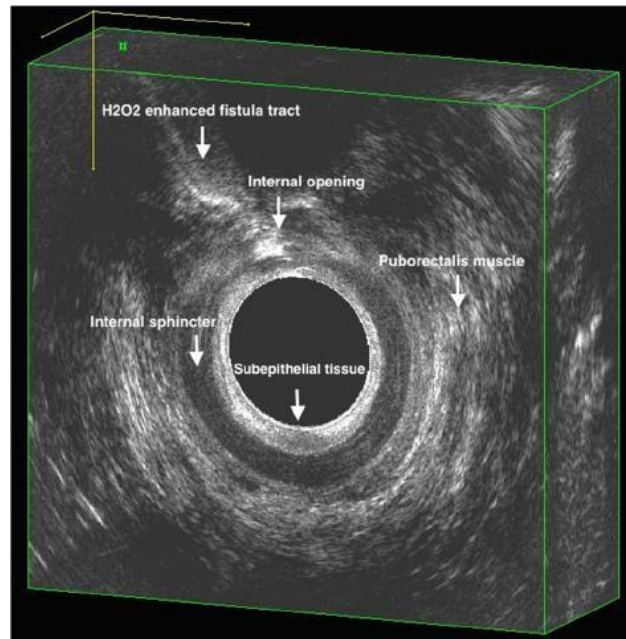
Endoanal Ultrasound (EAUS)
